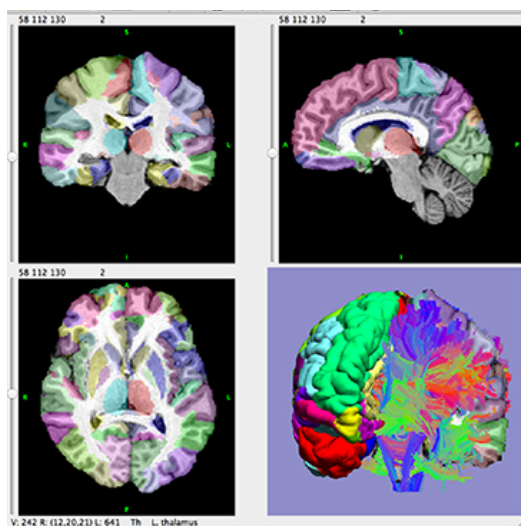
MR image analyzed by BrainSuite
